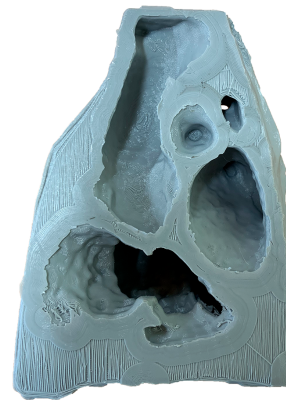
Result of the printing of the right section of the hollow model made with the CT scan of the heart of the patient with ToF. Left view.
